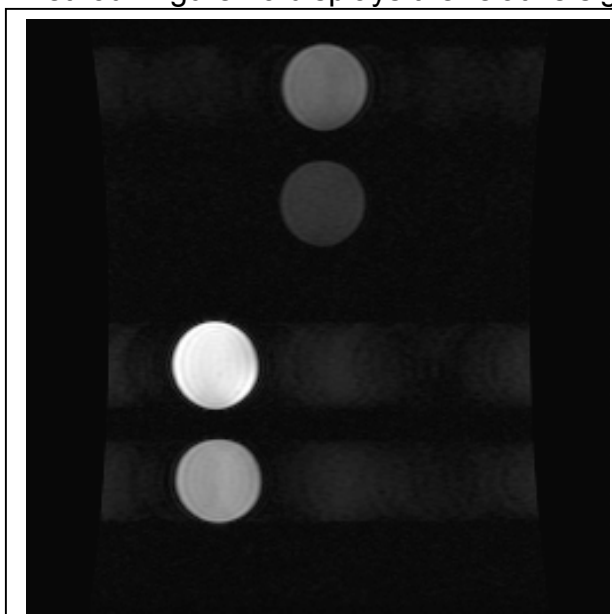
T2-weighted image showing greater signal loss in iron containing tubes compared with T1-weighted image (Figure 3).
